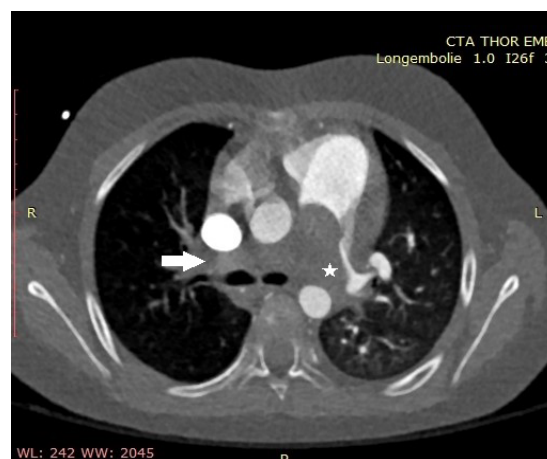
Computed Tomography Angiography showing pulmonic artery.
